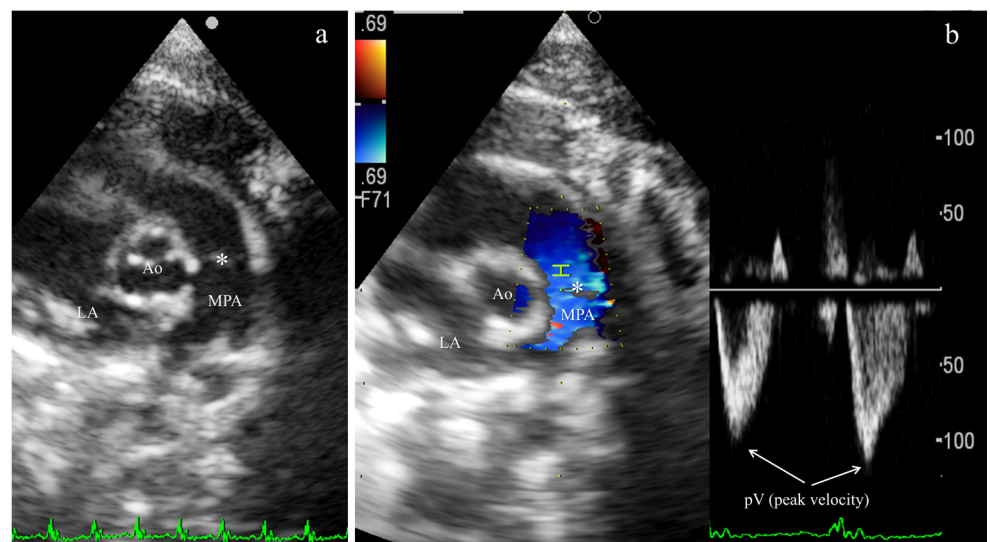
(a) Parasternal short-axis view at aorta-main pulmonary artery level; (b) indicating of the velocity of right ventricular outflow tract (RVOT) measured at pulmonic valve (asterisk), pV represents pulsed – wave Doppler velocity around 80.0 – 110.0 cm/s; LA/Ao ratio and pulmonic valve velocity are measured in this view; MPA = main pulmonary artery; Ao = aorta; * (asterisk) = pulmonic valve; LA = left atrium.
